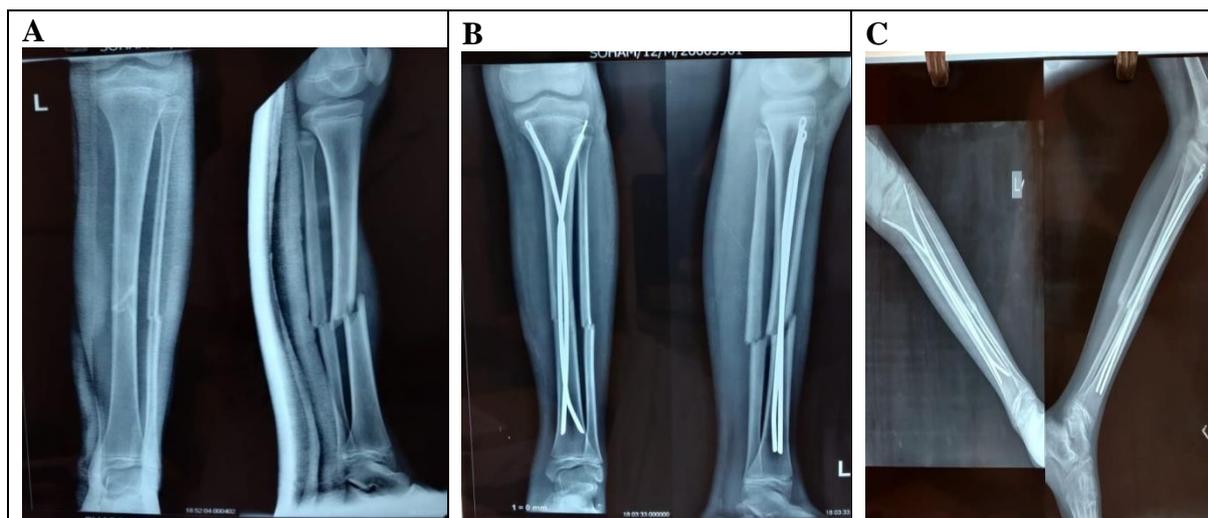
Radiograph of shaft tibia fracture of 7 year pediatric patient a) Pre operative b) Immediate post-operative c) Final follow up
